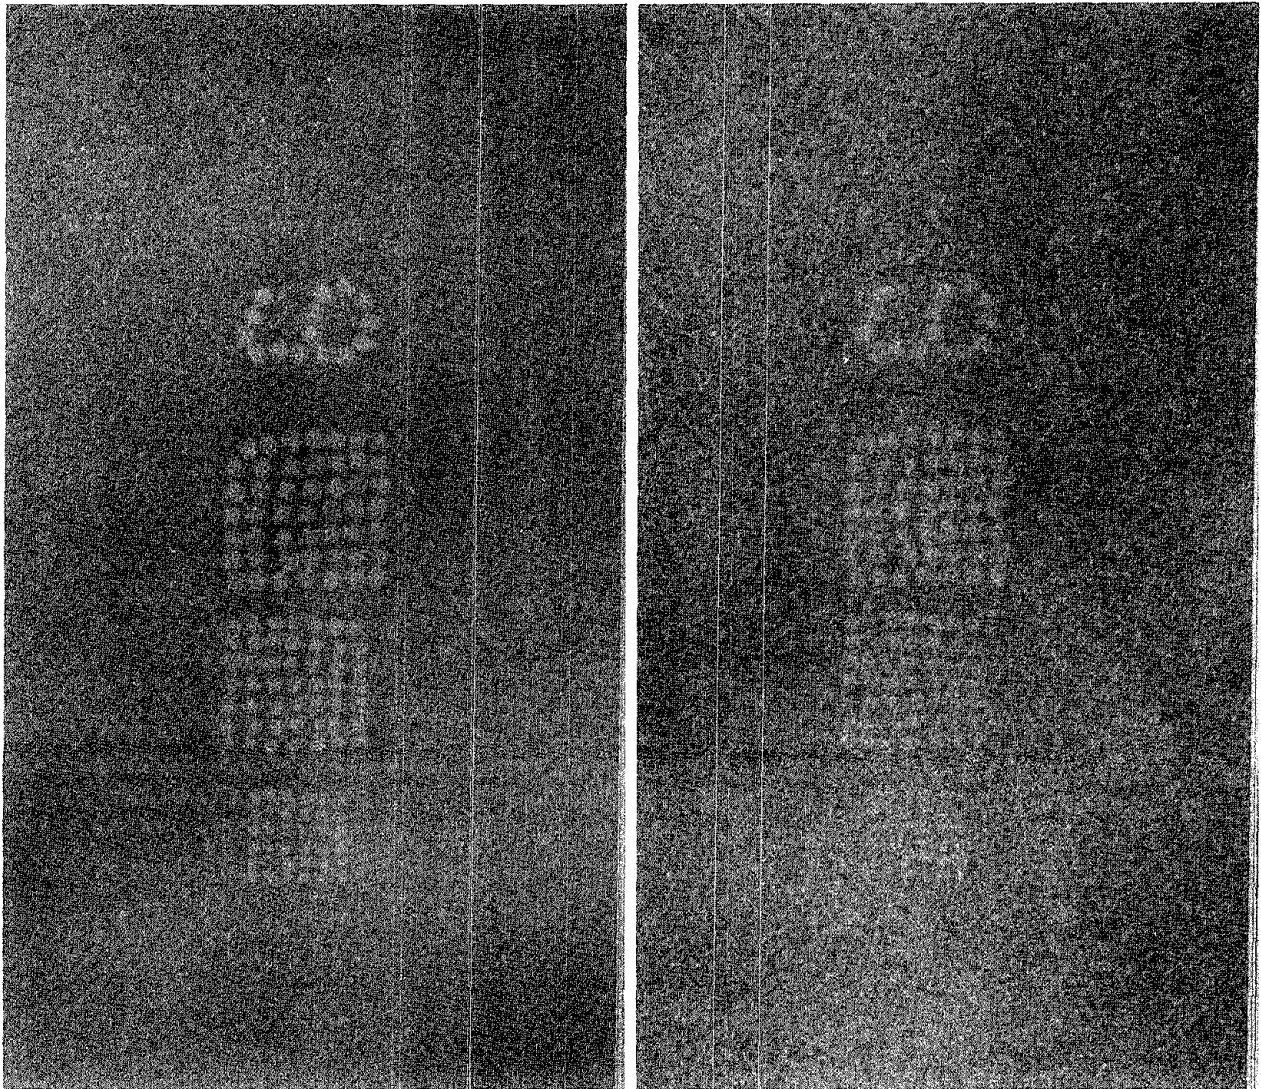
Effect of quantum mottle on image quality. Figure 2A (left): Radiograph of acetate beads made with a slow screen/film combination using many x-ray quanta. Figure 2B (right): Radiograph made with a fast screen/film combination using relatively few x-ray quanta. Note loss of detail and unsharpness of outline of the acetate beads.
